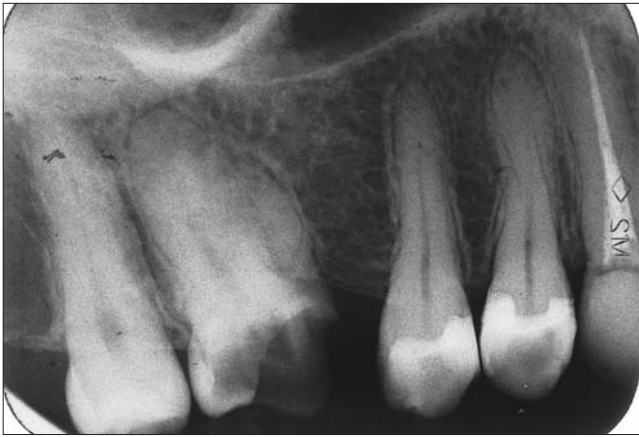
Preoperative radiograph of maxillary right second molar.
